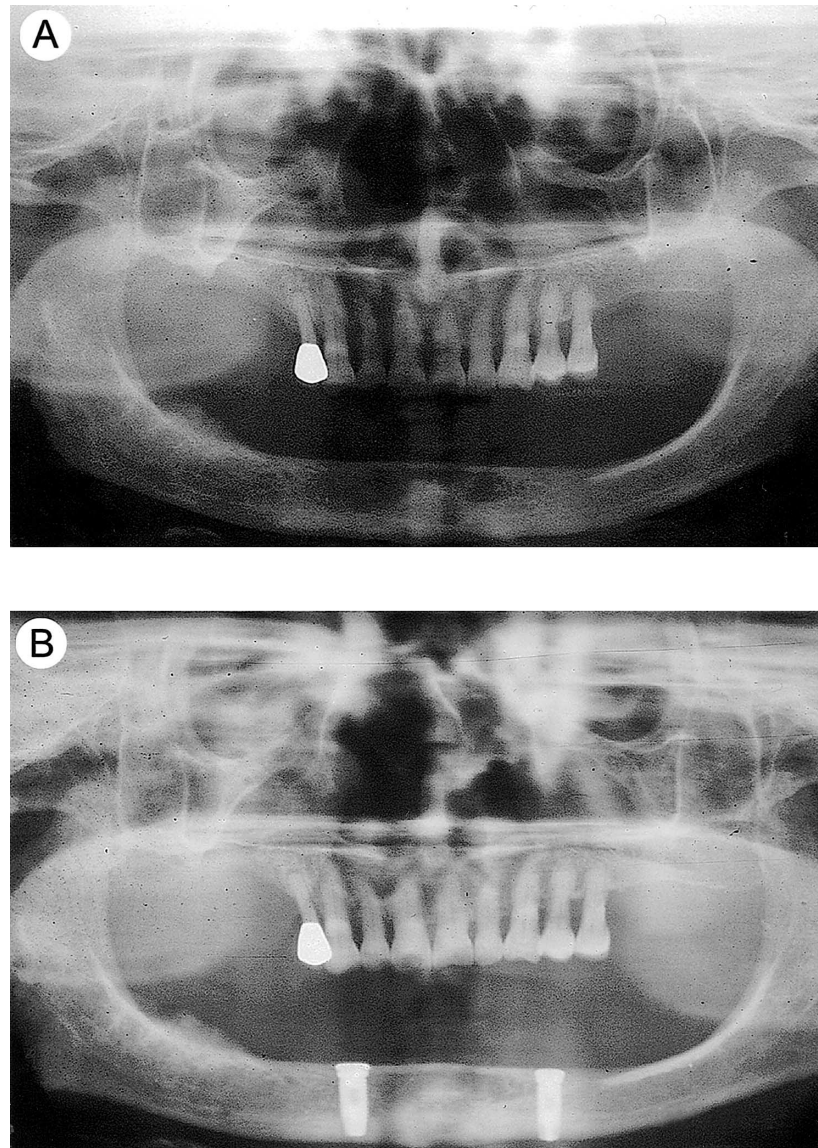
Radiographs of the same patient as in FIGURE 1. (A) A vertical bone height of approximately 2.2 cm at the symphysis area. (B) Excellent integration between host bone and two 18-mm implant fixtures 5 months after surgery.
